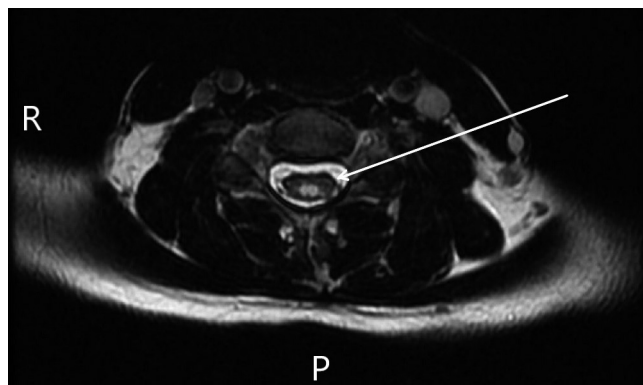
Axial spinal cord magnetic resonance imaging: typical involvement – T2-weighted image revealing a bright spotty lesion (white arrow).
